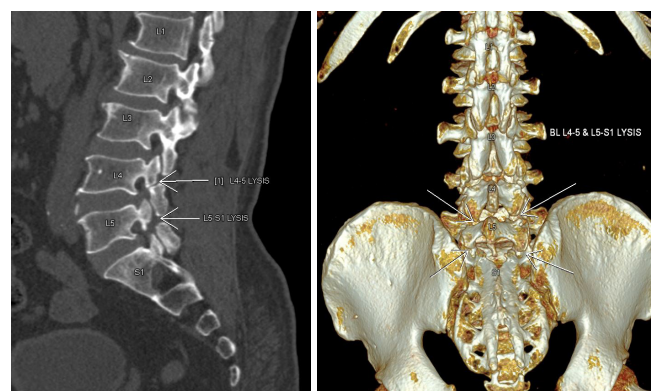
a) Sagittal CT MPR image of L4-5 and L5-S1 spondylolysis (arrows) b) Posterior view of 3D CT image of bilateral L4-5 and L5-S1 spondylolysis (arrows)
